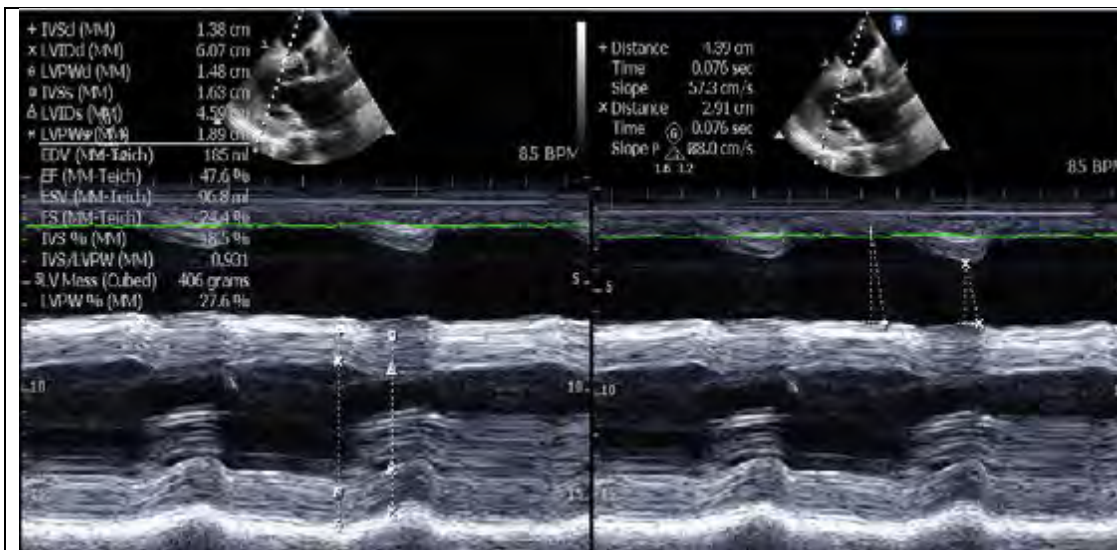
Parasternal Long Axis view with the M-mode cursor at the TV and the LV. Left image: M-mode image showing how LV measurement is done. Right image: M-mode showing RV measurement
